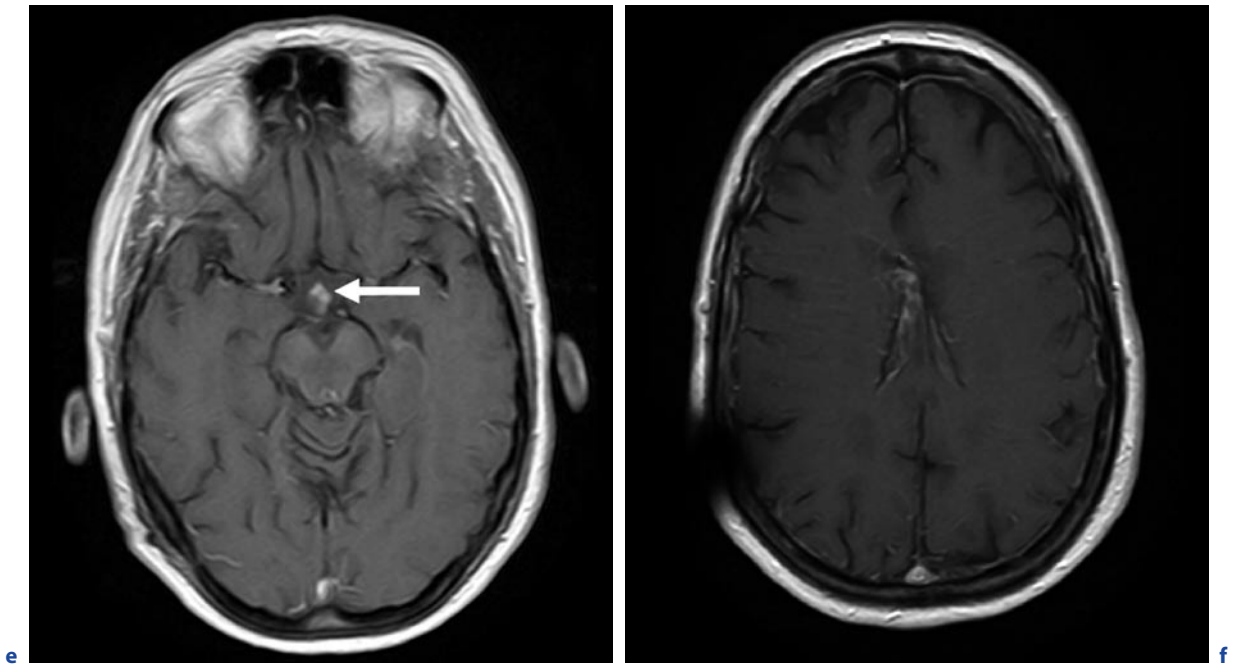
(continued) Typical manifestations of neurosarcoidosis. a Axial T2-weighted image. b Axial FLAIR image. e,f Axial T1-weighted image after contrast administration. Enhancing granulomatous tissue in the fourth ventricle (c, arrow) and the adjacent parenchyma of the medulla oblongata
